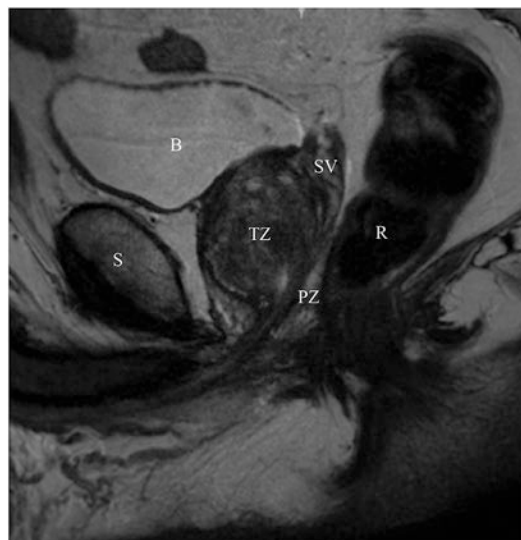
Sagittal T2-weighted image of the prostate. *S* symphysis pubis, *B* bladder, *TZ* transition zone of the prostate, *PZ* peripheral zone of the prostate, *SV* seminal vesicle, *R* rectum
